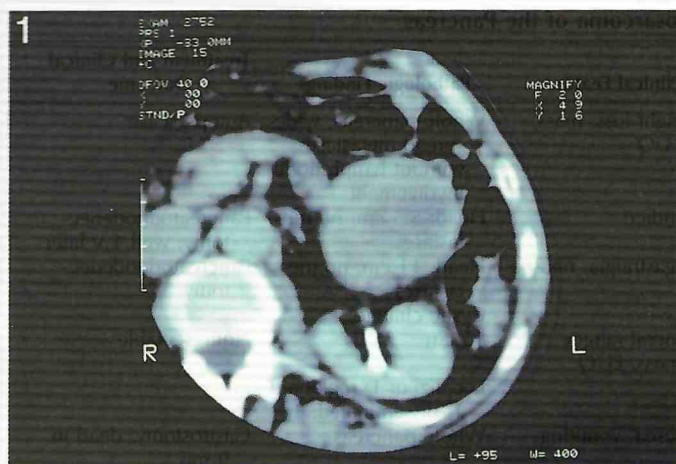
Computed tomographic (CT) scan showing a solid mass in the tail of the pancreas.
